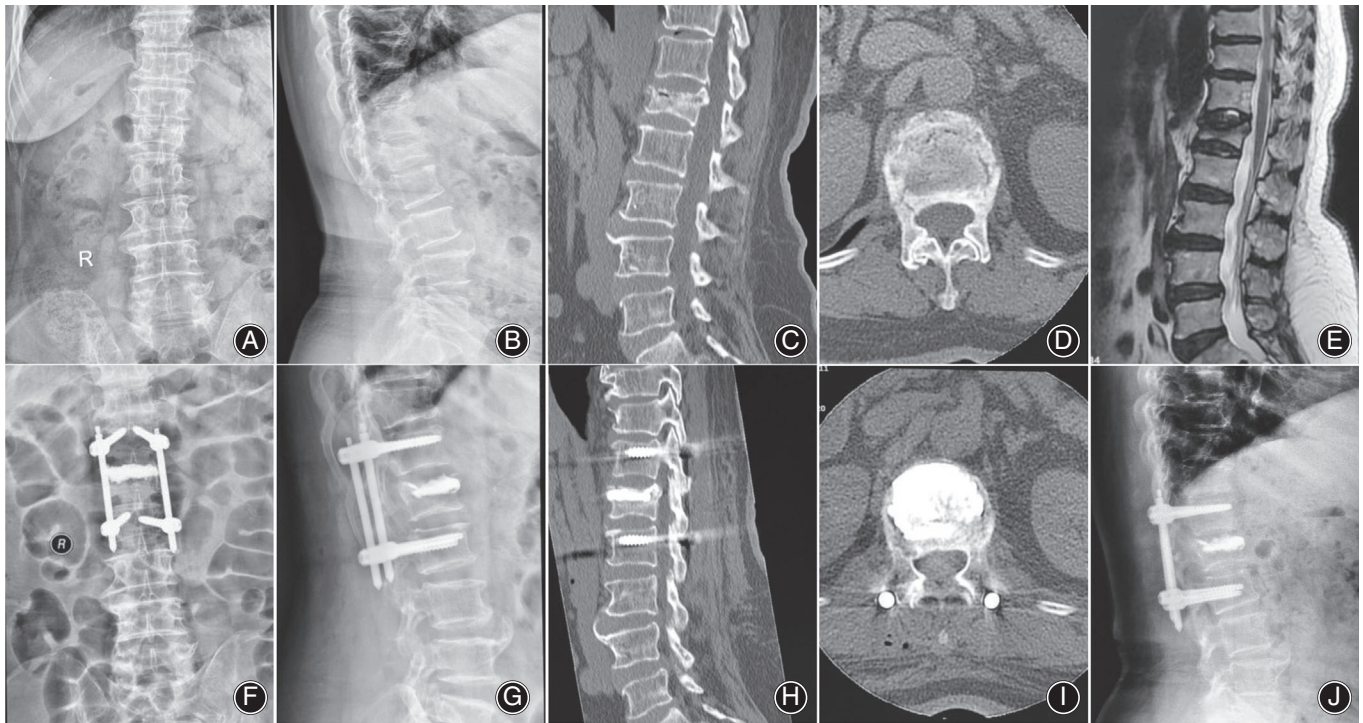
A 67-year-old-female patient who underwent percutaneous fixation combined with vertebroplasty for L₁ Kümmell disease. (A–E) Preoperative imaging showed L₁ vertebral fracture with Kümmell changes. (F, G) Postoperative X-ray showed fine bone cement position and Kümmell disease vertebral body height recovery. (H, I) Postoperative CT showed bone cement filling and fine internal fixation position. (J) Postoperatively 24 months X-ray showed firm internal fixation, stable vertebral body height, and fine bone cement position.
